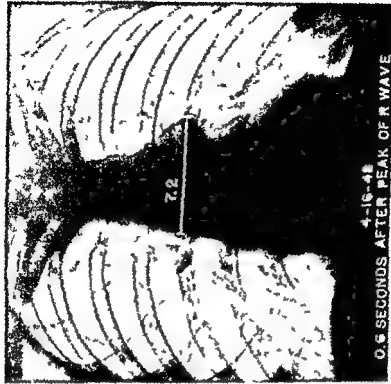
Roentgenograms made during the same phase of the cardiac cycle (diastole) and respiration 4-12-48 before treatment with VCIH 4-16-48 Immediately after completion of treatment with VCIH
